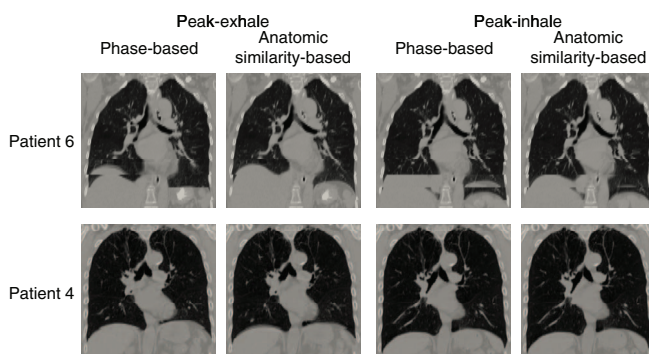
4D CT images (peak-exhale and peak-inhale) sorted based on phase and anatomic similarity for patients 6 and 4. Patient 6 showed the greatest decrease in the artifact score from 1.1 (phase-based) to 0.48 (anatomic similarity-based) at peak-exhale, and from 1.4 to 0.83 at peak-inhale. Patient 4 showed the smallest change in the artifact score from 0.42 to 0.43 at peak-exhale, and from 0.43 to 0.43 at peak-inhale.
